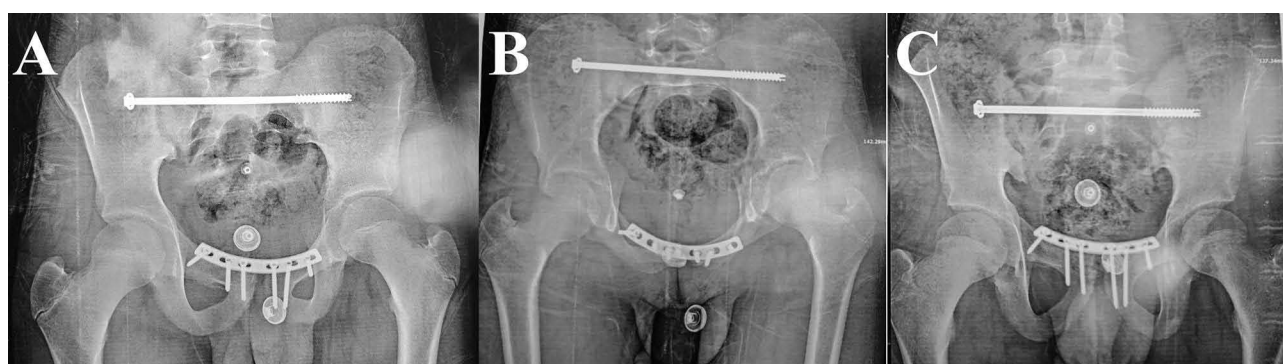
Plain radiographs (A) anteroposterior. (B) inlet. (C) outlet views obtained at the final follow up (at three months) showed the addition of a transiliac screw (which was inserted to fix the posterior element disruption), maintained symphyseal reduction, and union of the right pubic rami fracture.
